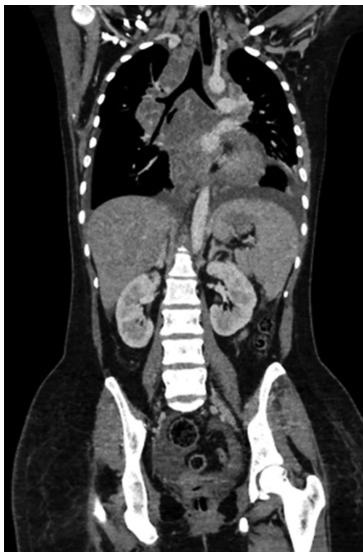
CT film showing diffuse thickened pericardium with left pleural effusion
